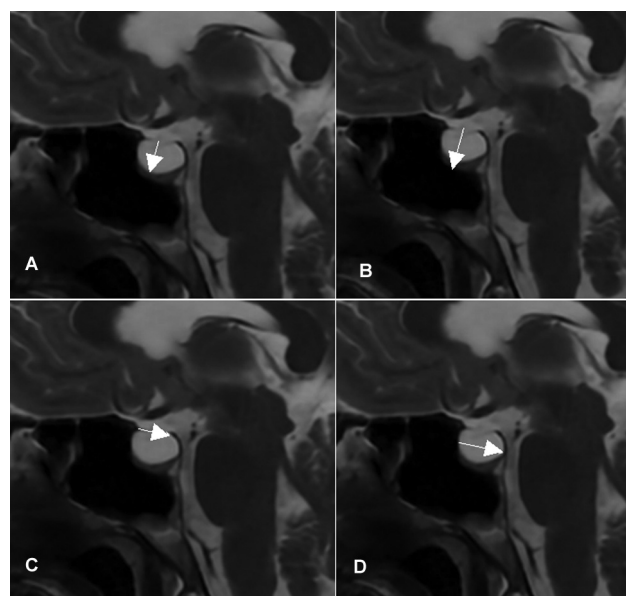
The pictures obtained from the sagittal MR images show the morphological measurement methods of the subarachnoid space invading the sella tursica (A), the maximum height of the sella tursica (B), the width of the sella tursica (C), the width of the diaphragm sella (D).
